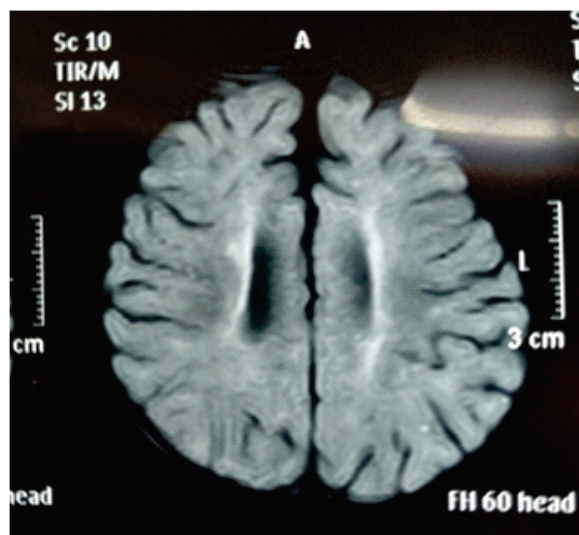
MRI Brain- Periventricular leukomalacia
